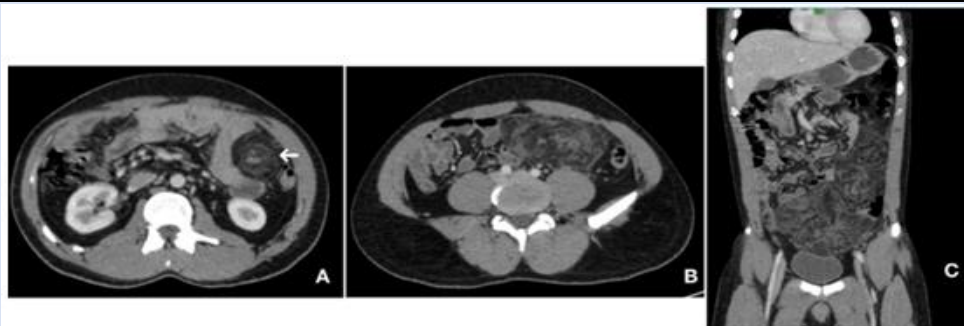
A, B, C–Omental torsion with infarction in a 36-year-old male patient who came with acute abdominal pain. Figure 3A and 3B axial CT contrast images and Figure 3C coronal CT contrast images show swirling of vessels in an area of fat stranding in the left side of abdomen and in the pelvis representing omental torsion.
